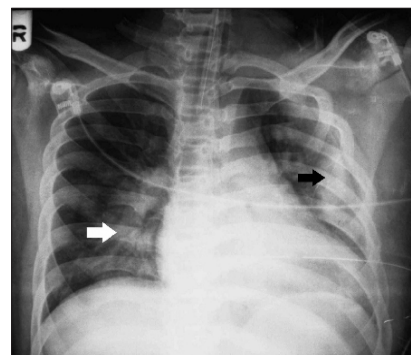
Chest x-ray showing right lower lobe infiltrate (white arrow) in addition to the left pulmonary contusion (black arrow).
